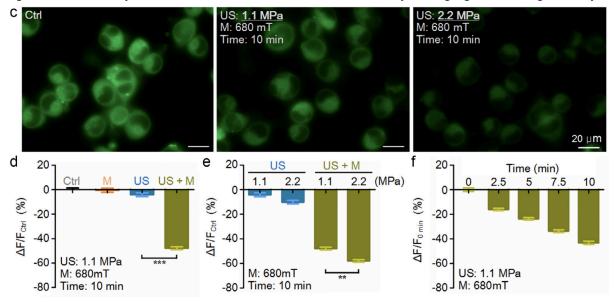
Figure from <u>Hu 2019</u> demonstrating reduction in fluorescent intensity of DIBAC4(3), signifying hyperpolarization over 10 minutes only in the presence of ultrasound and a static magnetic field.
